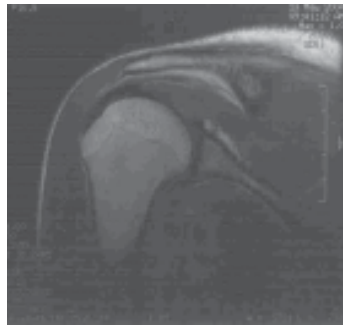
Postoperative shoulder MRI.
